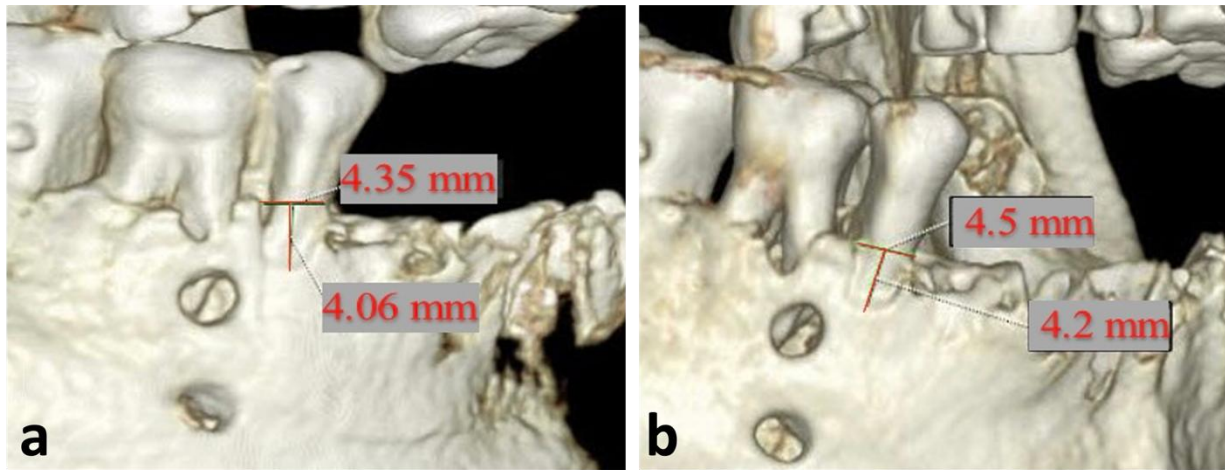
Measurements of the created dehiscence defect (a). High-resolution CBCT (b). Standard resolution CBCT on 3D volume rendering.
